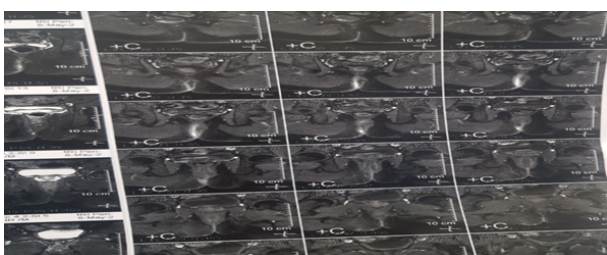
Shows an MRI with high linear perianal fistula.
